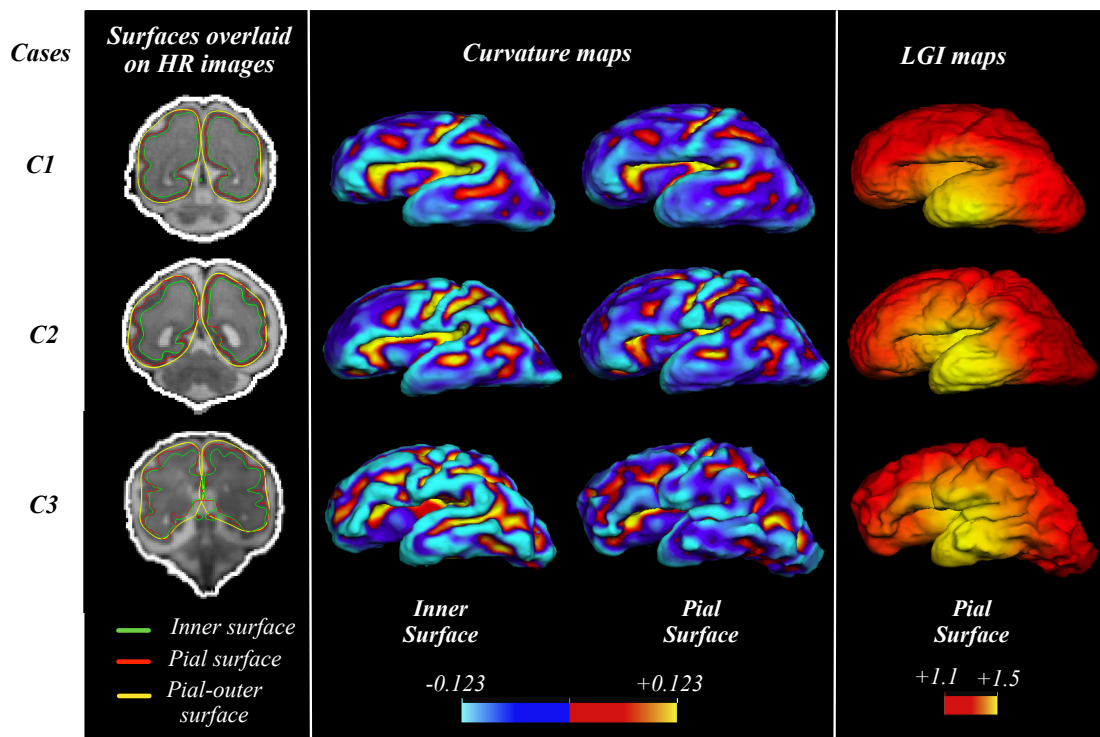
Reconstructed cortical surfaces from fetal MRI and resulting quantitative maps of cortical folding for cases C1, C2 and C3 diagnosed with normal brains.
